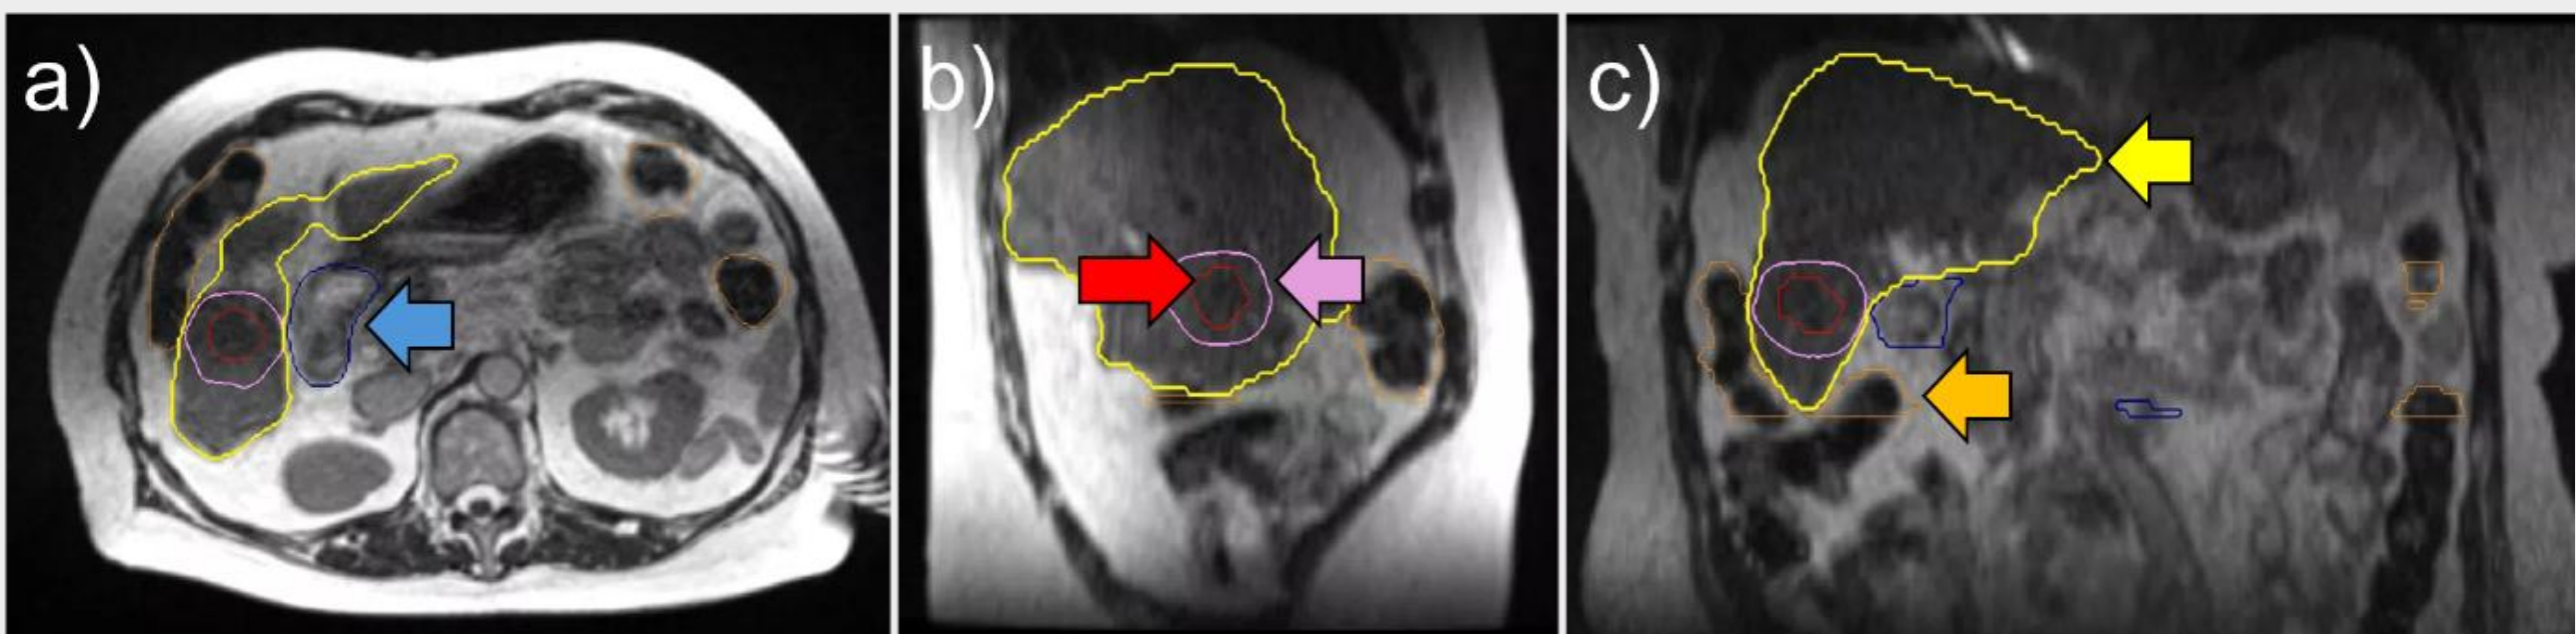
The lesion was treated to a definitive dose of 50 Gy in 5 fractions using free-breathing gating on exhale. Treatment was administered on a 0.35T MRgRT system (MRIdian A3i: ViewRay Systems Inc., Oakwood Village, Ohio). Planning contours of the tumor (red), whole liver (yellow), critical organs-large bowel (orange), and duodenum (blue) are shown with the 36 Gy isodose line (pink) on a) axial, b) sagittal, and c) coronal views of a 3D contrast-enhanced MRI.
